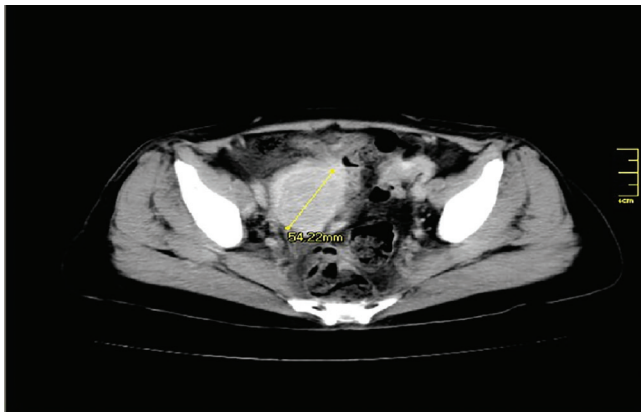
CT scan of the pelvis showing an inhomogeneous solid formation measuring 51 mm at the right paramedian level, in close continuity with the uterus and adnexal region.
